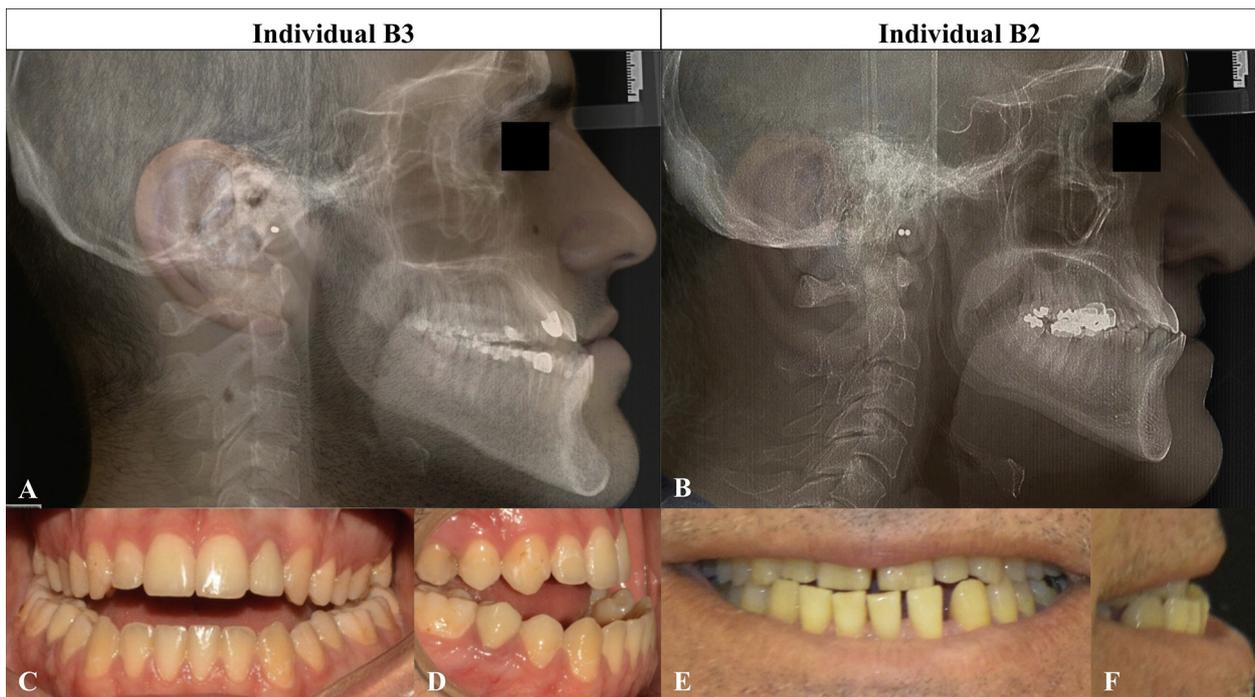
Superimposition of the facial profile photograph on the lateral cephalometric radiograph of A, subject B3, age 24.4 years, and B, his father (subject B2), age 54.10 years, revealing mandibular macrogynathism. The corresponding front and right lateral occlusal photographs (C-D and E-F) reveal the more severe anterior crossbite of the son.
